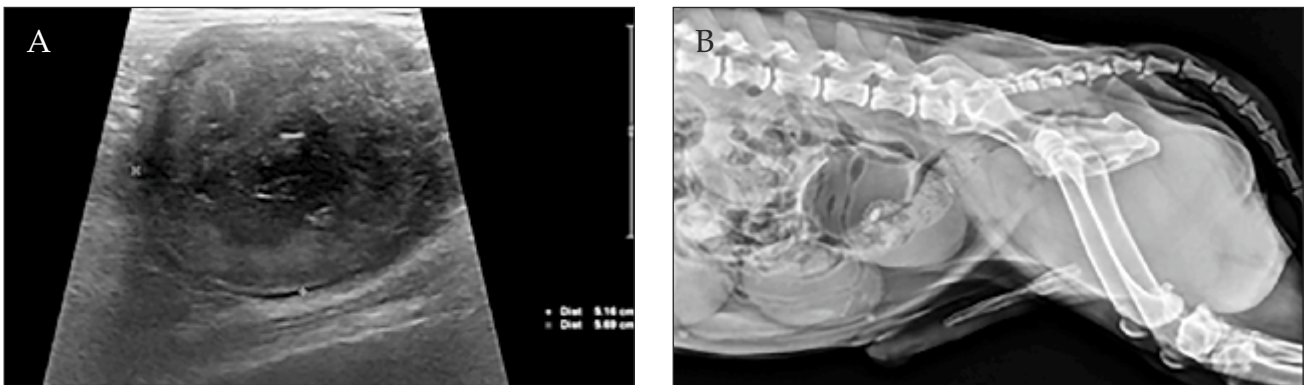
(A) Ultrasonographic image of mesenteric abscess measuring 5.16 x 5.69 cm; (B) radiograph showing the location of mesenteric abscess (arrows).
